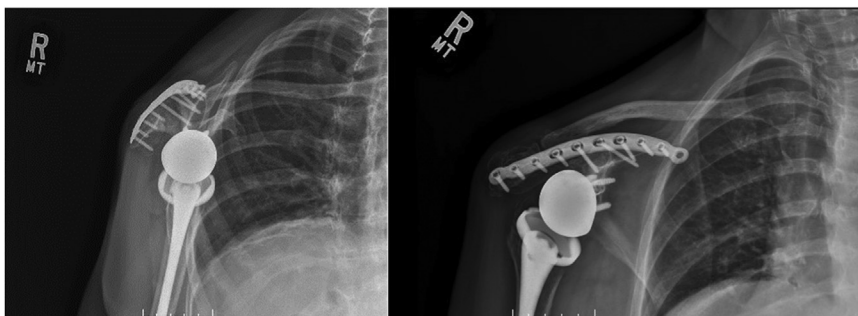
Radiographs of the right shoulder taken approximately 2 weeks postoperatively.
